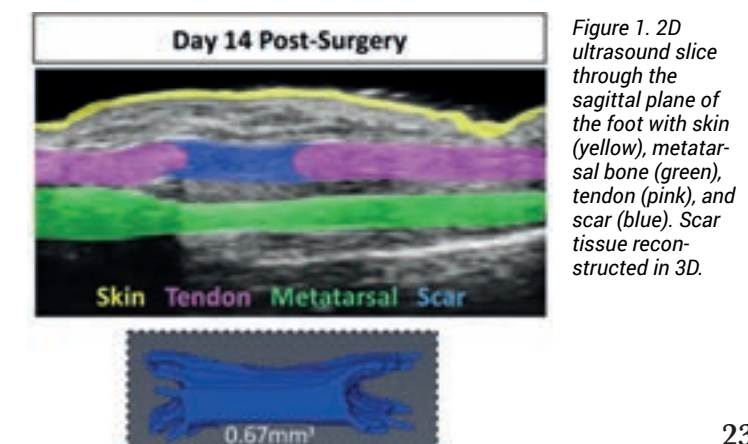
2D ultrasound slice through the sagittal plane of the foot with skin (yellow), metatarsal bone (green), tendon (pink), and scar (blue). Scar tissue reconstructed in 3D.
